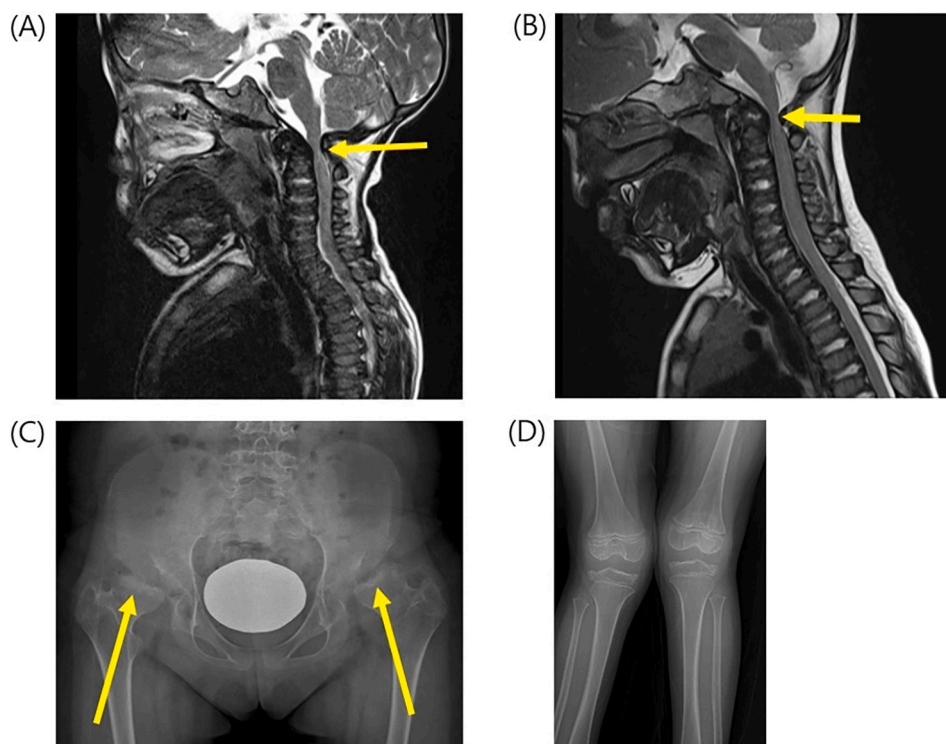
Radiologic examination of patients with MPS IVA. (A) C-spine MRI of a 3.1-year-old boy (P1), showing indentation of the spinal cord at C1 by arch posterior side during flexion. (B) C-spine MRI of a 2.0-year-old boy (P2), showing a prominent C2 cartilage bump with narrowed spinal canal at the craniocervical junction. (C) Hip radiograph of a 12.2-year-old girl (P6), showing bilateral hip subluxation and deformed femoral heads. (D) Standing knee X-ray of a 4.7-year-old girl (P3), showing dysplastic epiphyses of the proximal tibia and genu valgum.
